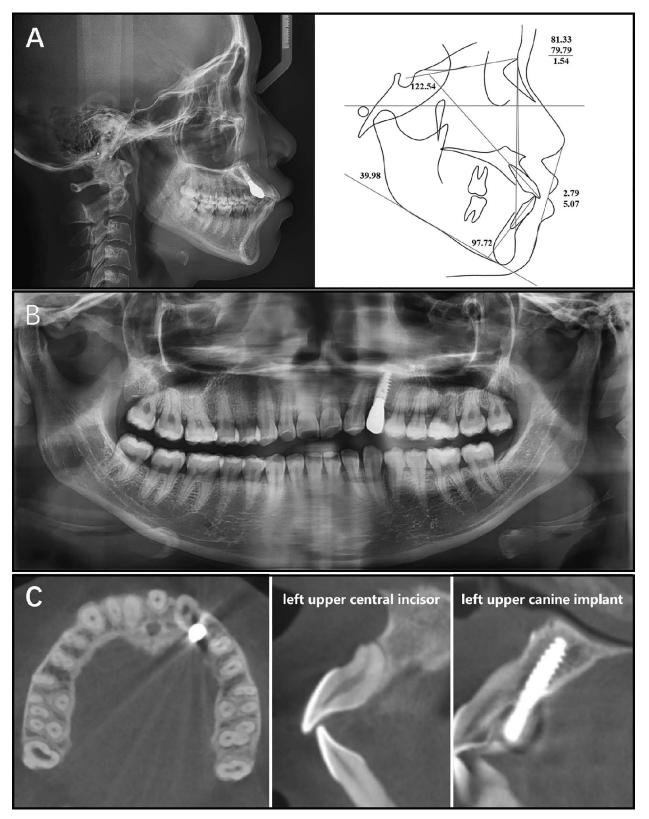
Pretreatment radiographs. (A) Lateral cephalogram with tracing. (B) Panoramic radiograph. (C) CBCT. CBCT indicates cone beam computed tomography.
